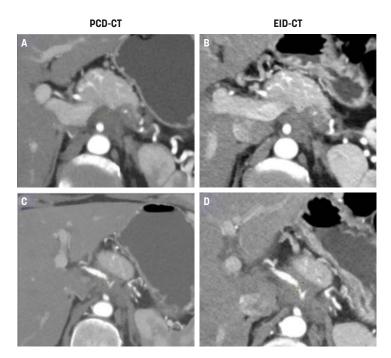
Zoomed images of EID-CT (right) and PDC-CT (left) in a pancreatic cancer patient, analyzed regarding image quality parameters in ViewDex 3.0.
